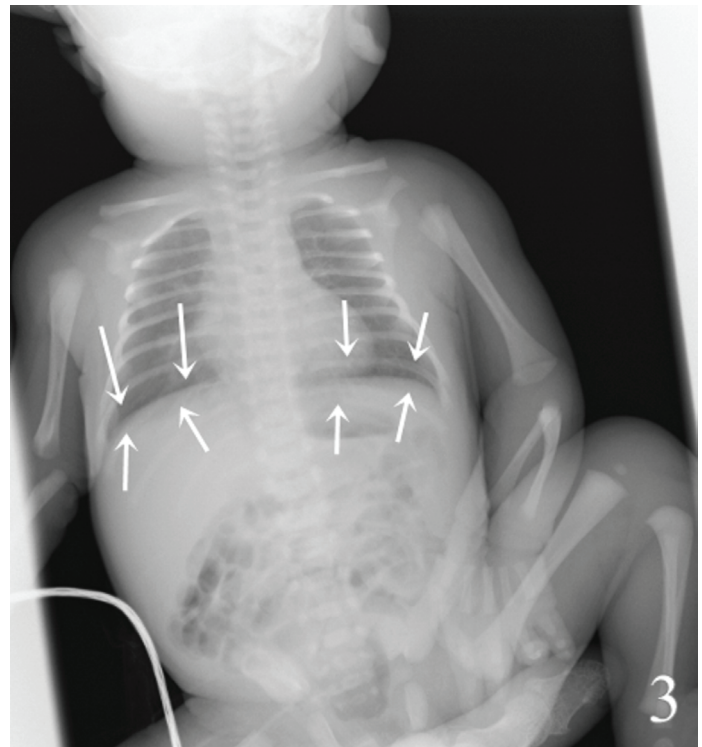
Postoperative second day abdominal plain radiography of the same baby. Free air is lost (Arrows).
